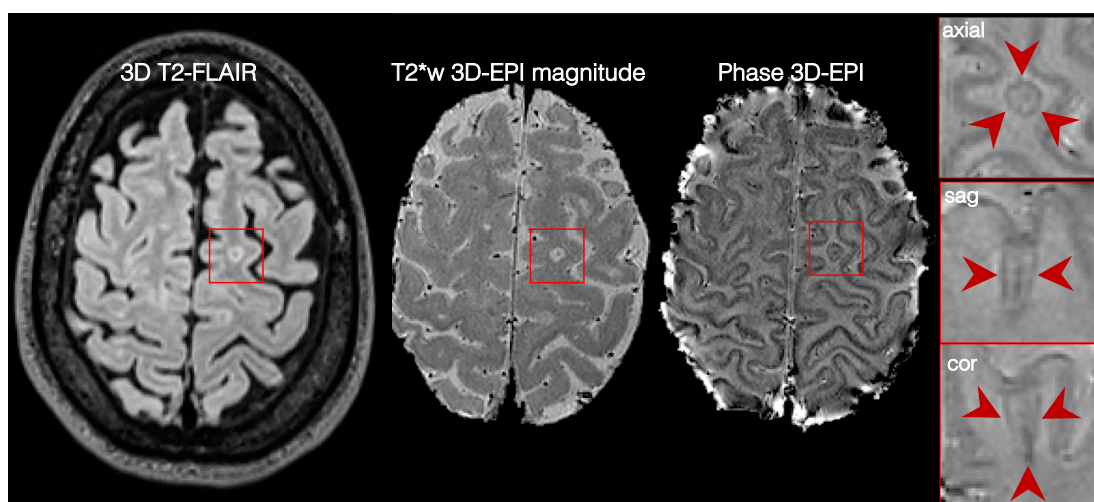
A central vein running through a lesion visible in the three planes (magnified views) in a 3D FLAIR\* obtained at 3T. Resampling was applied to the magnified images for visualization purposes.
